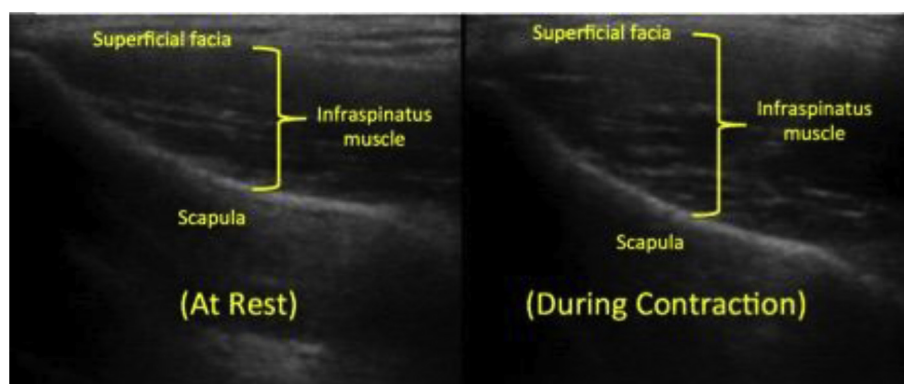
Infraspinatus muscle thickness measurement on ultrasound image.
